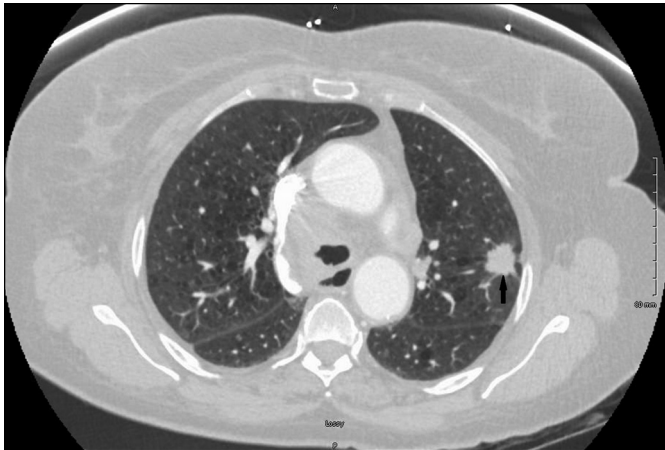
Chest computed tomography scan with contrast showing a left upper lobe spiculated nodule (arrow), which is consistent with primary lung cancer.
